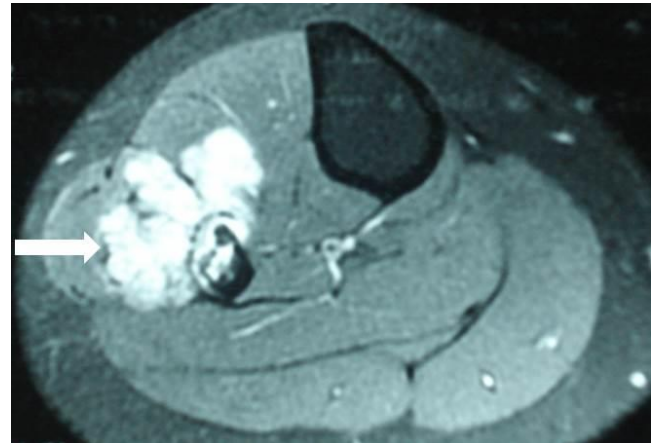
T2-weighted axial MRI image showing extraskeletal tumour at the anterior and lateral part of the right leg.
